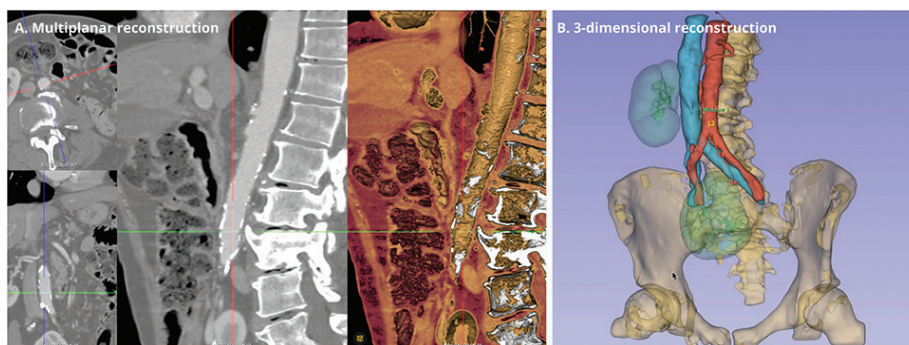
Computed tomography reconstructions of iliofemoral arteries: Severe bilateral atherosclerosis and calcifications with a functional kidney donor on the right side.
